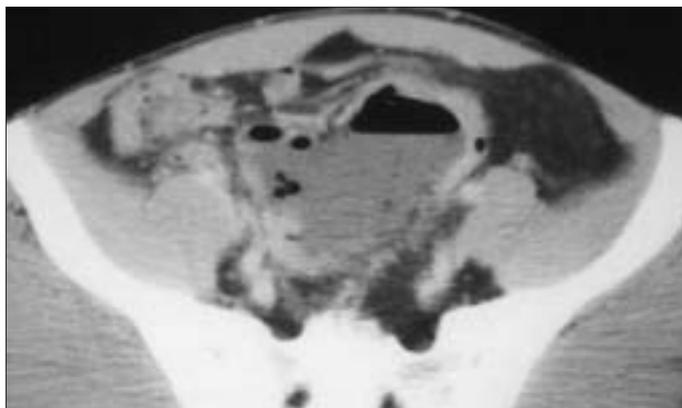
Axial CT image shows air-fluid level due to an abscess in an appendicitis case.
